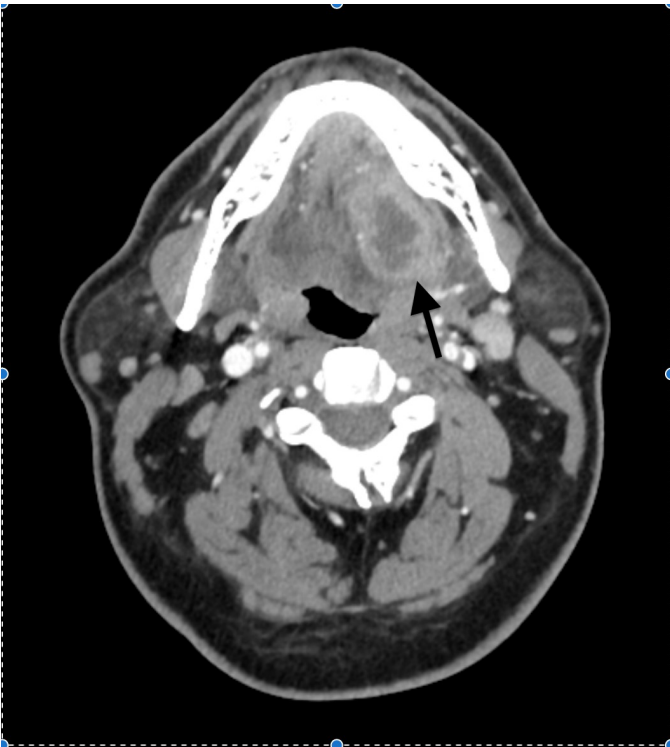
A contrast-enhanced axial computed tomography image showing a tongue abscess (arrow) characterized by a hypodense lesion with peripheral rim enhancement on the tongue.
